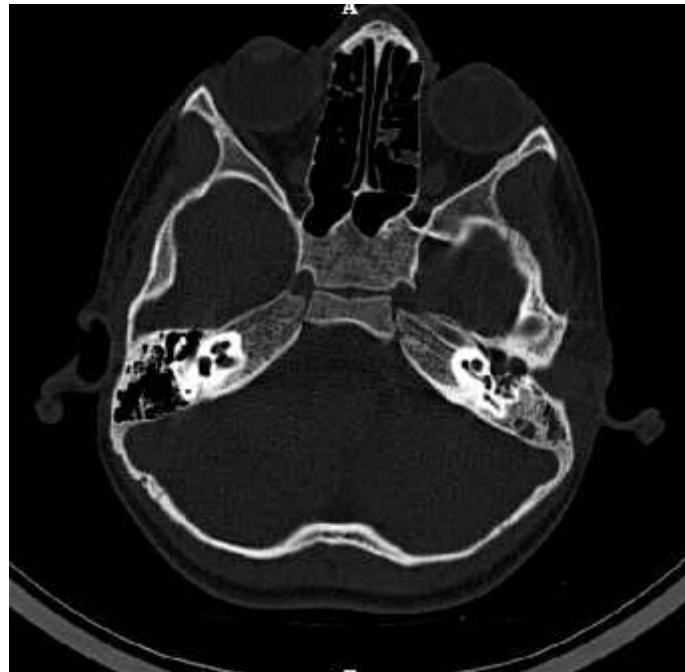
HRCT Axial and coronal reformatted bone window images showing evidence of soft tissue density noted within the left middle ear cavity involving the aditus, antrum and Prussac's space. There was also destruction of scutum, incus, stapes and part of posterior aspect of head of malleus noted. Mild erosion and sclerosis with soft tissue density within is also noted within the mastoid cavity.
